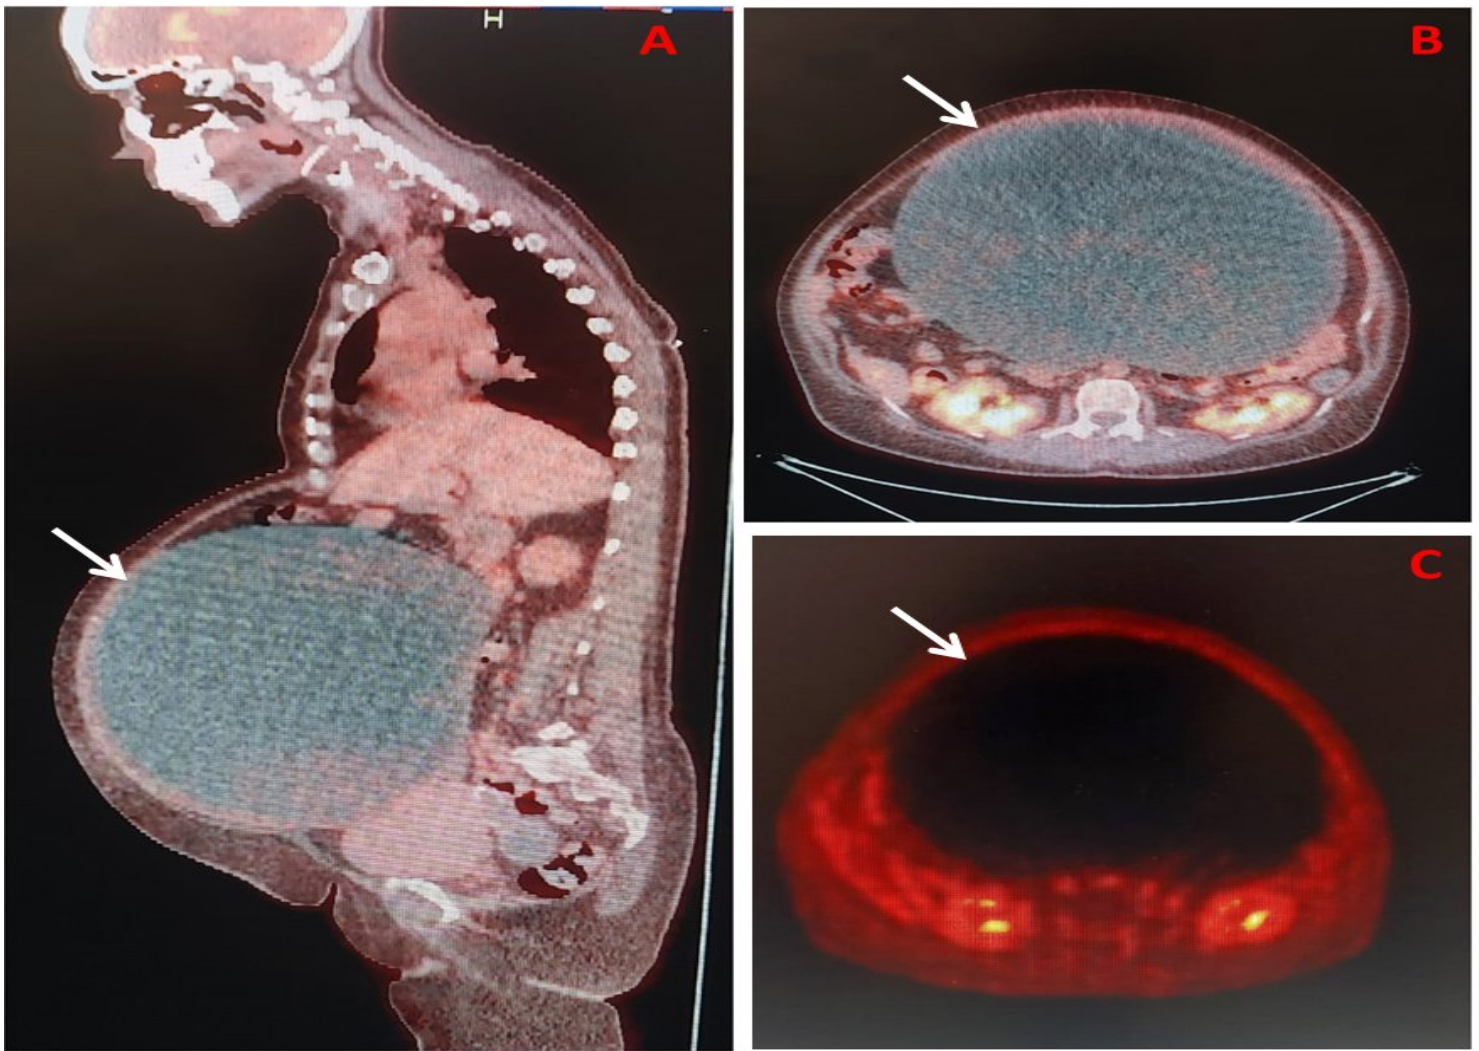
A representative image to demonstrate the false negative. 66 years woman with ovarian cancer. (a-b) sagittal & axial 18F-FDG fused PET/CT images of sizable ovarian lesion (arrow) with no significant increased fdg
